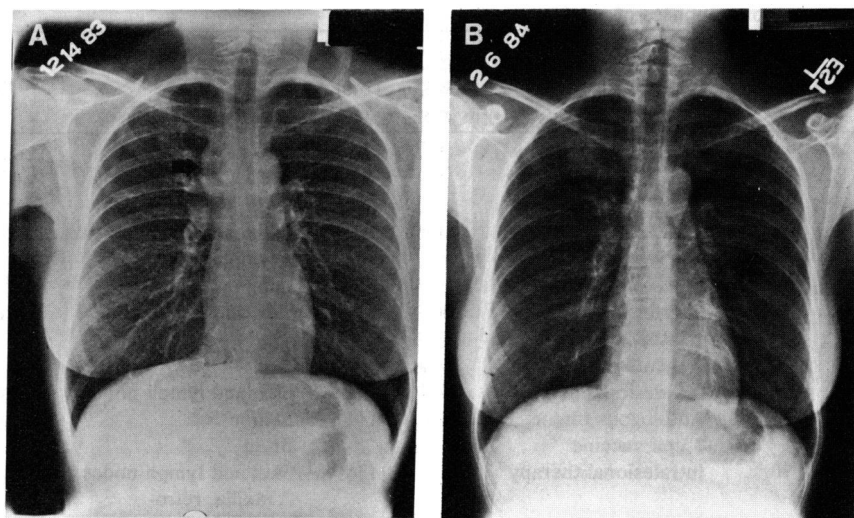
Chest x-rays of patient 3. (A) At end of  $R_{24}$  treatment (no change compared with pretreatment x-ray). (B) Eight weeks later. The arrow points to the paratracheal mass.
